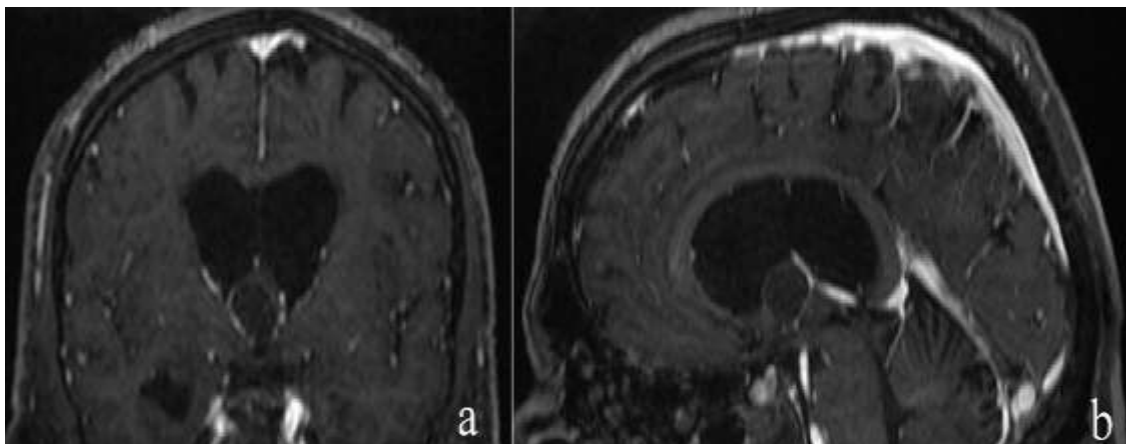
Preoperative MRI: a- coronal T1 + contrast showing an isointense cyst projecting through the foramen of Monro with the venous system dropped over the edges of the cyst. b- sagittal T1 + contrast showing the position of the cyst and the interventricular foramina and the internal cerebral vein. a ventriculomegaly could be noticed favoring our transventricular approach.
